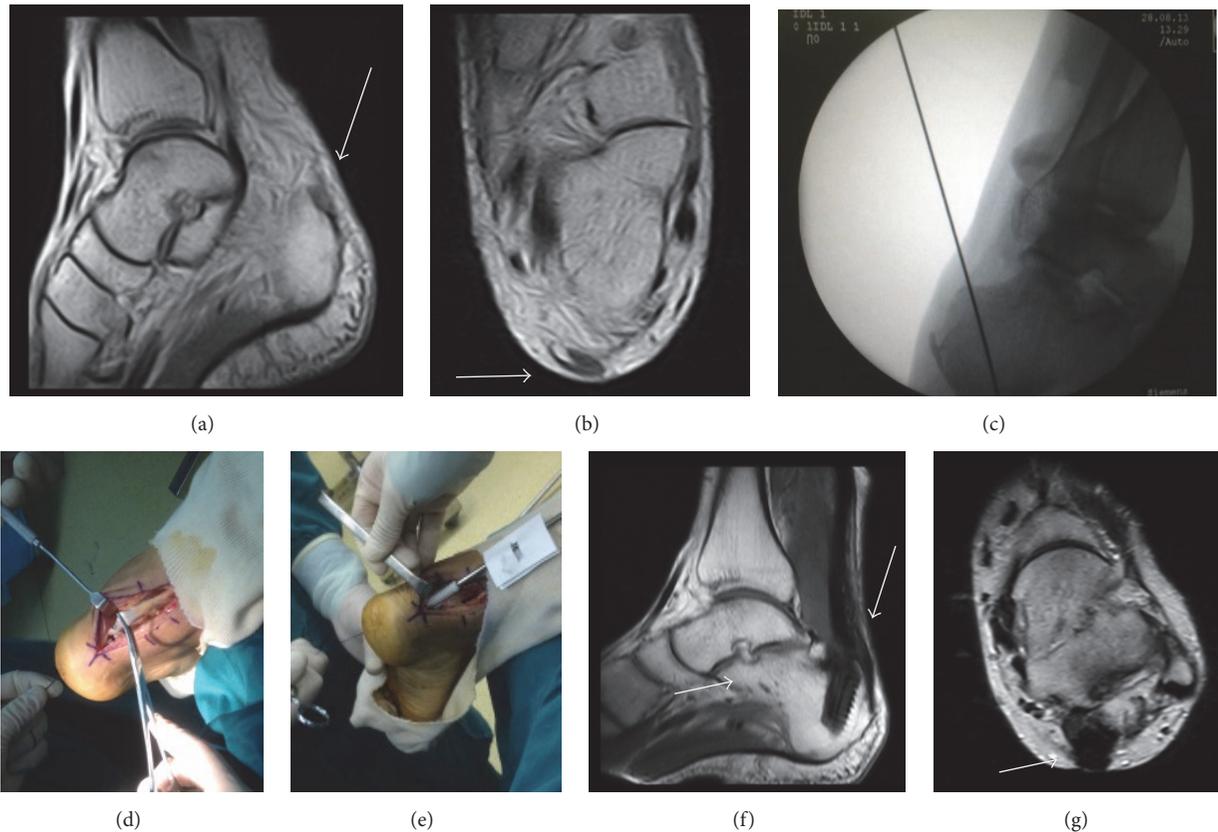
Preoperative MRI showed chronic Achilles tendon rupture and no stump at calcaneus (a, b). FHLT transfer performed (c, d). Using the screws of hydroxyapatite composition to fix FHL into the bone tunnels (e). MRI showing the continuity of the Achilles tendon and homogeneous low-signal at 34 months postoperatively (arrow) (f, g).
